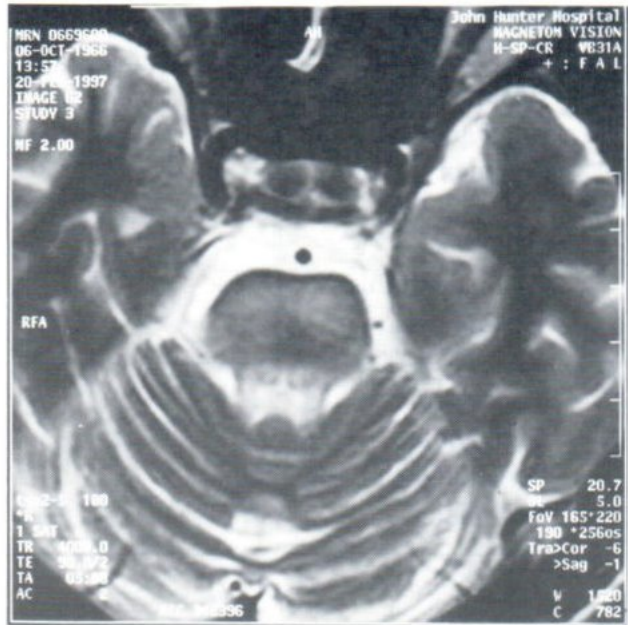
T2-weighted axial MR image through pons reveal increase signal intensity in central pons and superior cerebeller peduncle
